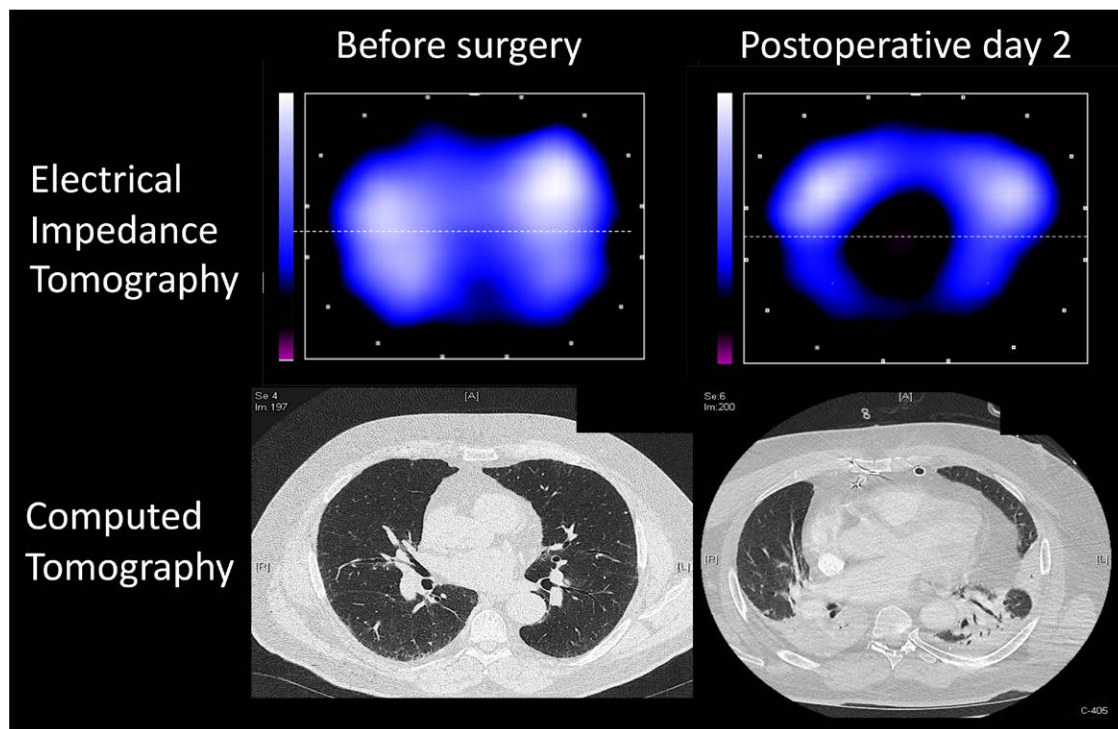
Pre- and postoperative regional distribution of the tidal impedance variation, assessed with lung electrical impedance tomography, in a patient presenting postoperative respiratory failure 2 days after coronary artery bypass graft surgery. Note that pulmonary atelectasis observed on computed tomography is associated with a reduced impedance variation signal in the dorsal hemithorax.
